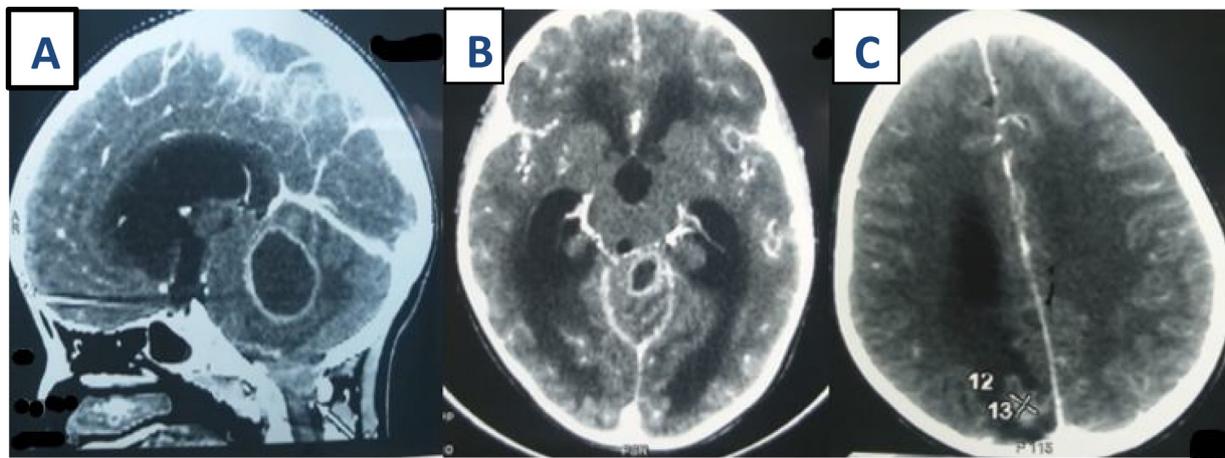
Cerebral CT A sagittal reconstruction, B and C axial section: showing a tuberculous cerebellar abscess with onset of engagement, responsible for hydrocephalus. Frontal and occipital tuberculomas.
